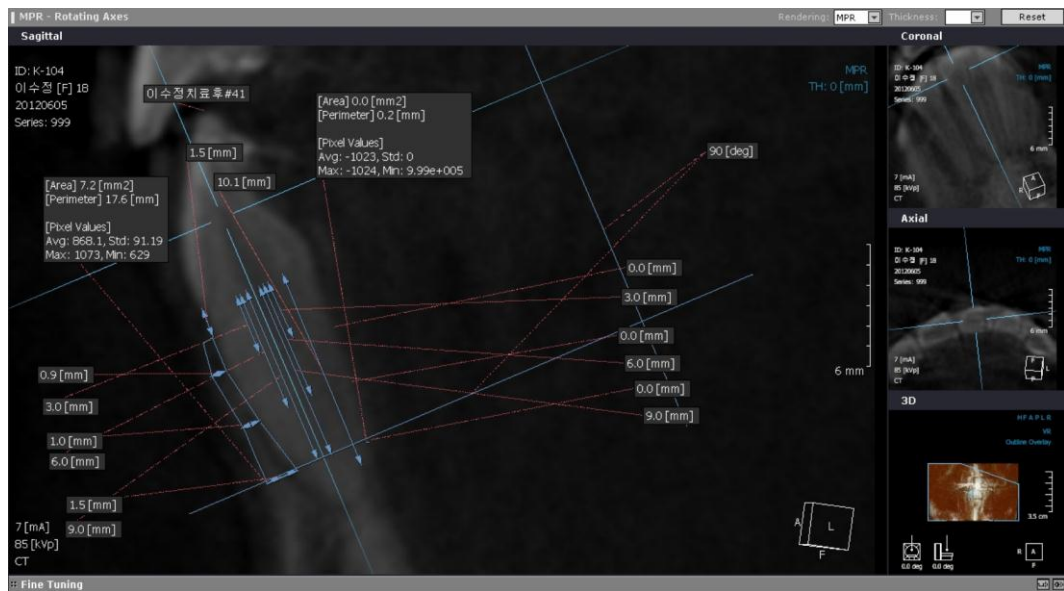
CBCT analysis of #41 after Treatment ( T2 )
